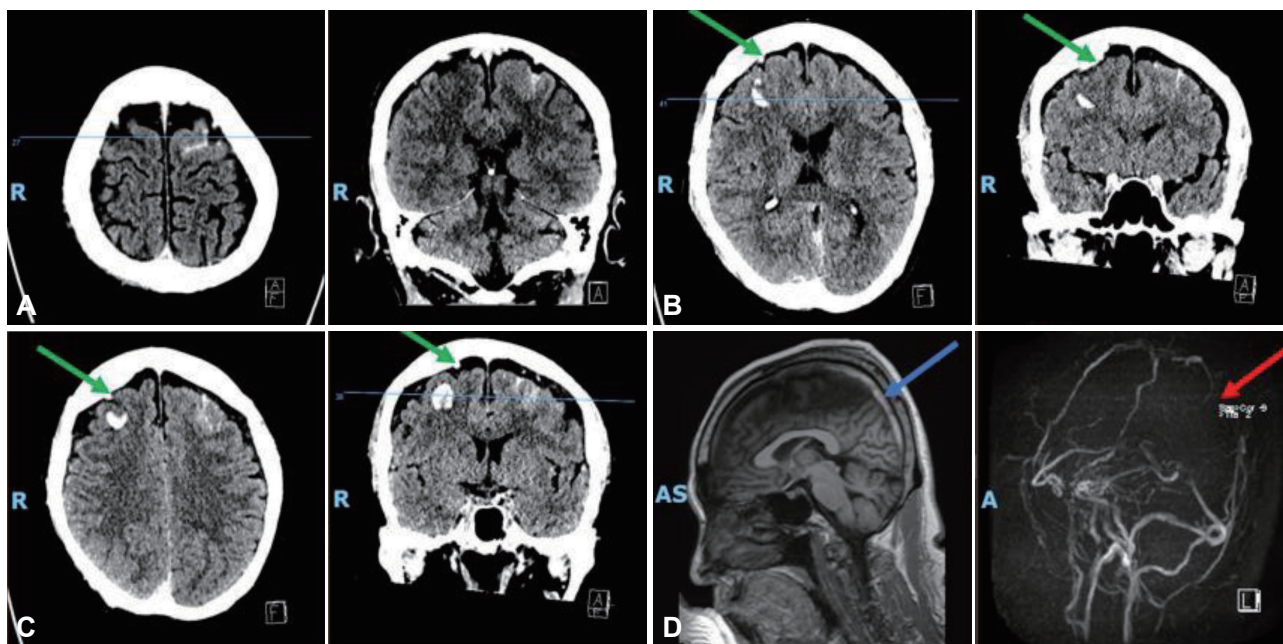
Neuroimaging showing intracerebral hemorrhages and cerebral venous sinus thrombosis. A: Axial and coronal brain CT on admission showing hyperdensities along the left frontal lobe sulci suggestive of SAH. B and C: Axial and coronal brain CT repeated 1 day later showing several new acute intraparenchymal hematomas in the right frontal lobe with sizes up to 1.3 cm. There were also hyperdense cortical draining veins over the right frontal lobe (green arrows). The left frontal lobe sulci SAH was stable. D: Sagittal brain T1-weighted MRI (left image) showing T1-weighted hyperintensity over the entire SSS (blue arrow) extending to the right transverse sinus, compatible with thrombus. The MRI venogram (right image) reveals that flow was absent in the SSS (red arrow). SAH, subarachnoid hemorrhage; SSS, superior sagittal sinus.
